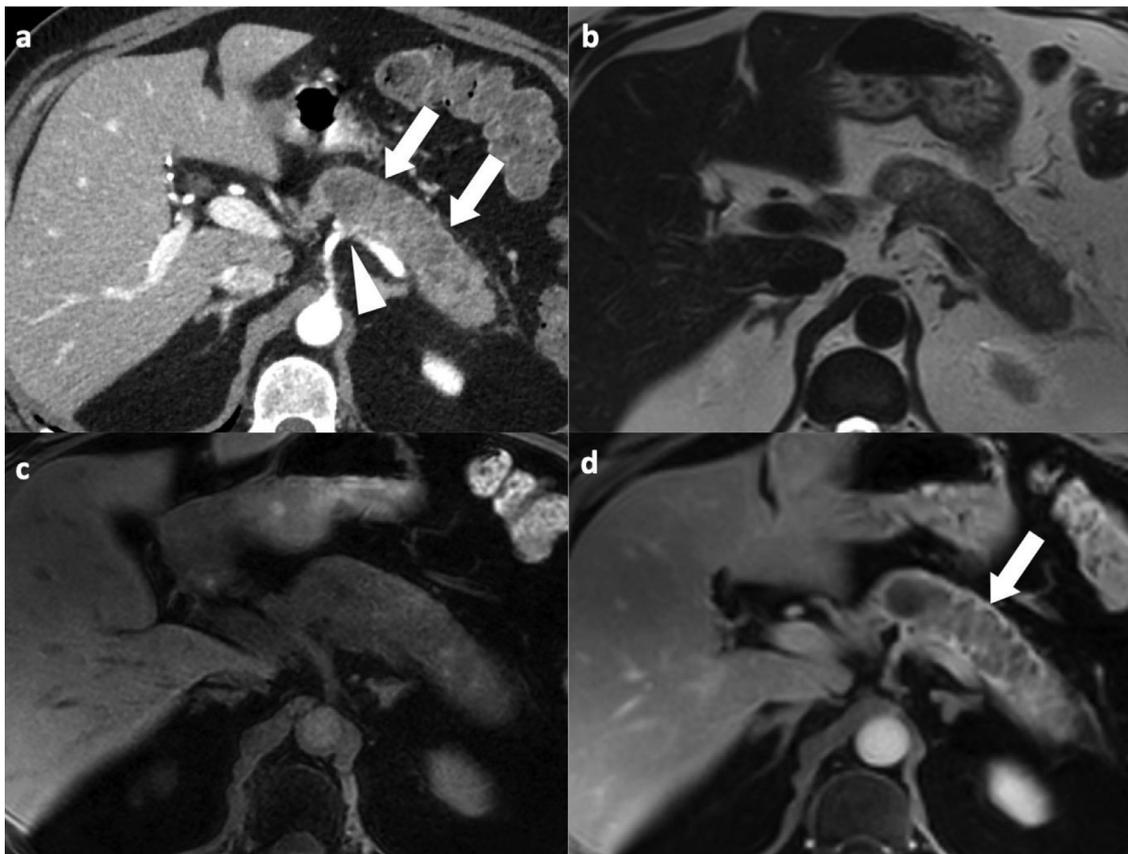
Acinar cell carcinoma in a 57-year-old male patient. Axial CT image obtained during arterial phase (a) shows a well-defined hypoattenuating mass (arrows) in the body and the tail of the pancreas. There is no peripancreatic fat stranding. The splenic artery is compressed by the tumor (arrowhead). The lesion shows mild T2 hyperintensity (b), heterogeneous hypointensity on a precontrast fat-suppressed T1-weighted GRE MR image (c) and is well delineated and hypointense with an enhancing capsule (arrow—d) on a fat-suppressed T1-weighted GRE MR image obtained during the portal venous phase (d).
